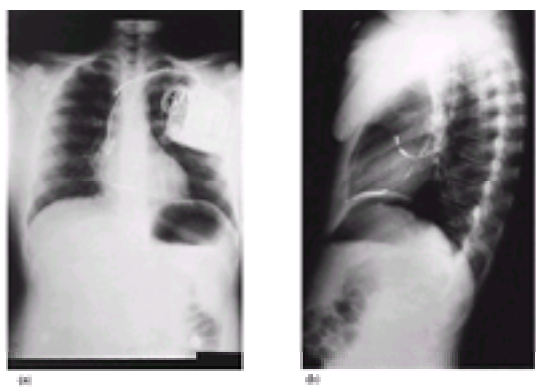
Posteroanterior (a) and lateral (b) chest radiographs of an 11-year-old, 120-lb (54.4 kg) boy with long QT syndrome and syncope. A dual-chamber, implantable cardioverter–defibrillator is present in the left pectoral position. The atrial pacing lead is curled in the right atrium with the tip in the atrial appendage. The defibrillator lead tip is in the apex of the right ventricle, with the distal electrode in the right ventricular chamber and the proximal electrode in the superior vena cava and the brachiocephalic vein. The active can of the defibrillator generator makes up the third component of the defibrillation vector in this system.
